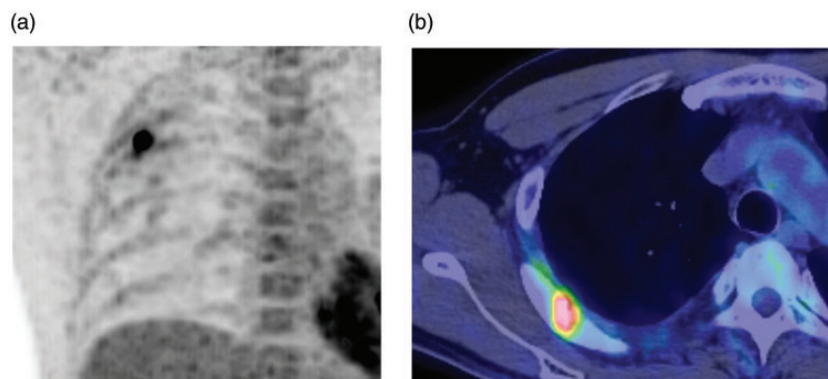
FDG-PET/CT. (a) Maximum intensity projection (MIP) image. (b) PET/CT fusion image. Combined FDG PET/CT was performed on a 16-multi-detector row CT (MDCT) scanner (Biograph 6 PET/CT, Emotion 16 CT, Siemens). Approximately 270 MBq of 18-F-FDG was administered intravenously as a bolus, and imaging was performed 60 minutes later. FDG-PET showed a strong FDG uptake as SUV max 12.0.
